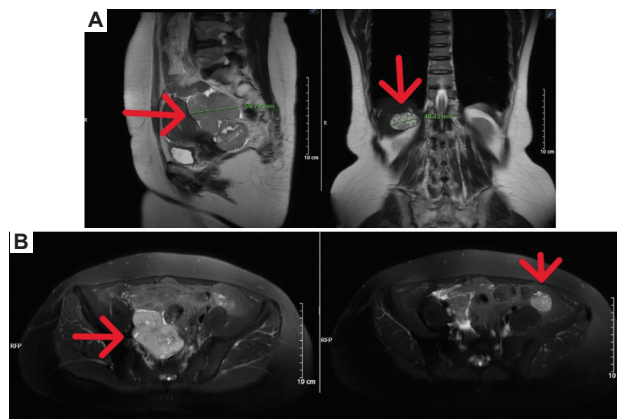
Pelvic magnetic resonance imaging findings. (A) Sagittal and coronal T2-weighted images demonstrate a well-defined, lobulated mass posterior to the uterus, measuring approximately $59 \times 83 \times 78$ mm, with heterogeneous signal intensity, internal septations, and possible hemorrhagic or cystic components, suggestive of a recurrent granulosa cell tumor. (B) Axial T2-weighted fat-saturated and diffusion-weighted images show multiple enhancing nodular lesions within the anterior abdominal wall, the largest measuring approximately 23×24 mm (red arrows). These findings are consistent with peritoneal implants or metastatic deposits.
